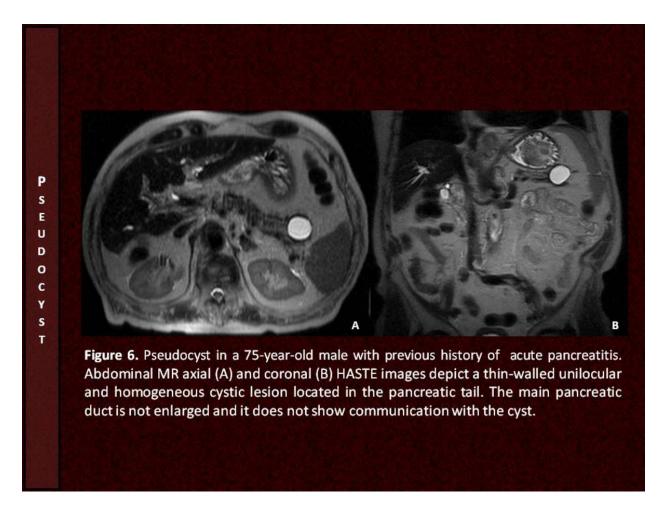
Pseudocyst - MRI
